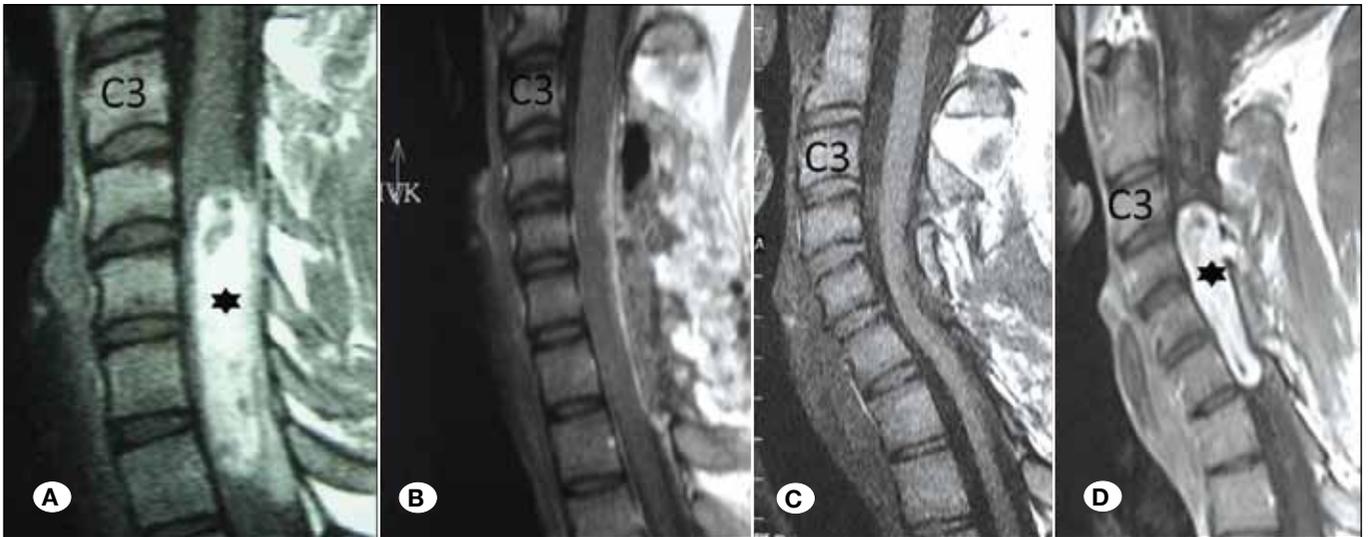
A) A well-circumscribed, oval-shaped large mass (asterisk) with contrast enhancement at C4-7 levels on sagittal T1-weighted MRI scans, B) Postoperative early follow-up MRI confirming total removal of the tumor on sagittal T1-weighted MRI with gadolinium, C) Follow-up MRI 2 years after the tumor excision with no tumor residue and no newly raised tumor, D) a new, well-circumscribed, oval-shaped large mass (asterisk) with contrast enhancement at C3-6 levels on sagittal T1-weighted MRI scans, 6 years after the previous tumor excision.
